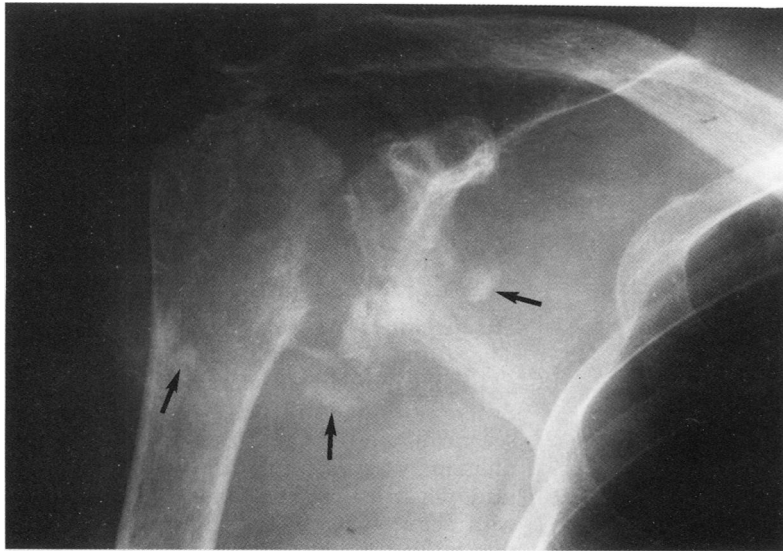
Repeat radiograph after two months shows marked destruction of the articulating humeral head and glenoid fossa. The amount of intra-articular debris has increased (arrows).
